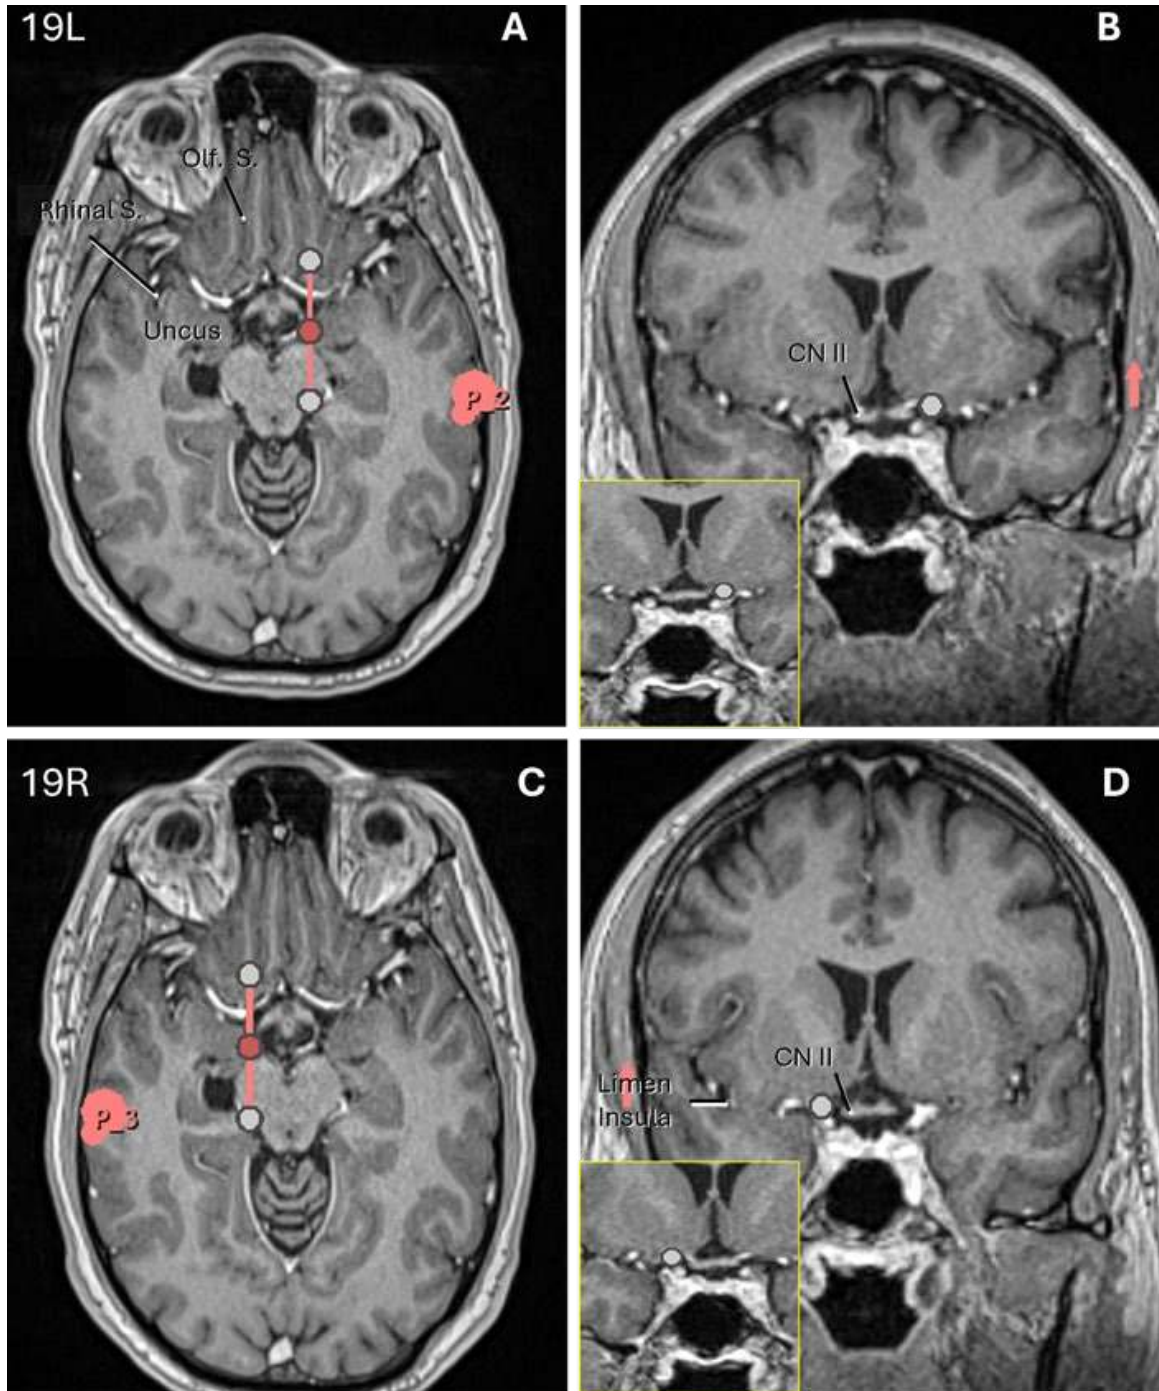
Left (A and B) and right (C and D) MRI scans of patient 19. The sagittal plane was plotted using the posterior part of the olfactory sulcus as seen on the axial scans (A and C). The coronal images (B and D) revealed that this plane was coincident with the carotid bifurcation (see enlarged inserts). It is noteworthy that the sagittal plane projected from the posterior portion of the olfactory sulcus coincide also with the medial uncus apex and the lateral mesencephalic sulcus. CN: Cranial Nerve; S.: Sulcus; Olf.: Olfactory.
